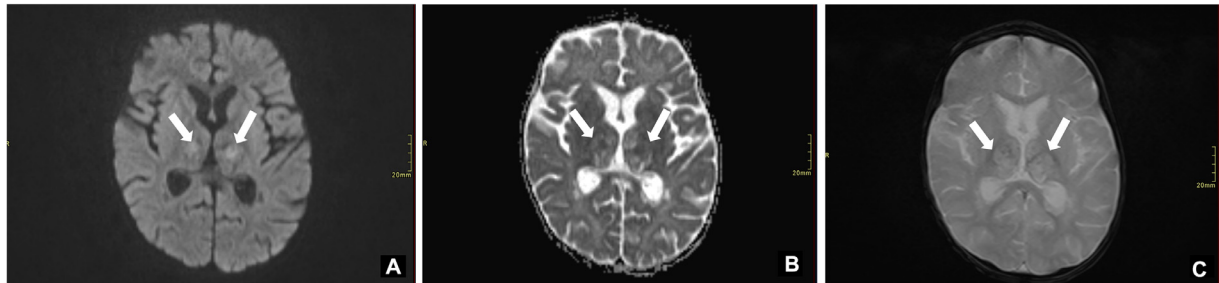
Bilateral abnormal signal intensities involving both the thalami. Axial images of the brain DWI (A), ADC (B), and GRE (C). These signals show restricted diffusion on DWI/ADC and areas of blooming on GRE sequences in keeping with blood products (Arrows).
